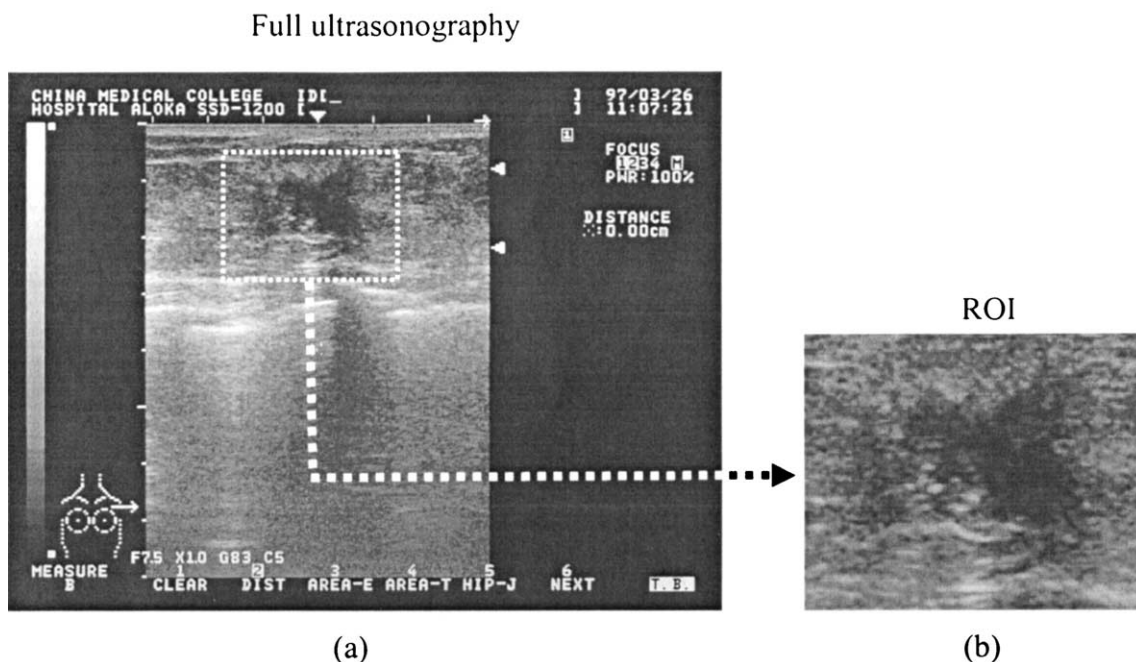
Full ultrasonography. (a) A 736×556 full breast sonography. (b) The ROI rectangle is approximately 2.91×2.33 cm in size, captured with a resolution of 169×135 pixels (a 1×1 cm rectangle contains 58×58 pixels).
